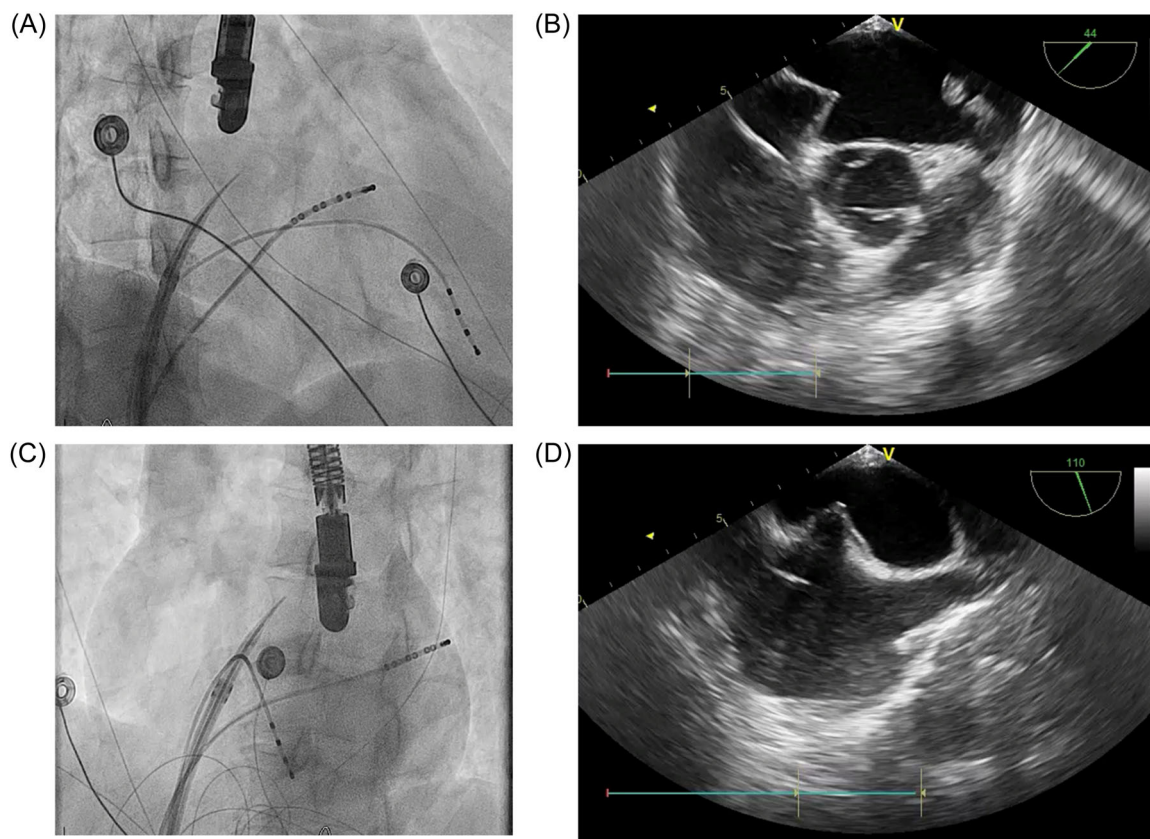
Positioning of the sheath with transseptal needle. (A) Antero-posterior adjustment, fluoroscopy, RAO 30°. (B) Antero-posterior adjustment, TEE short axis. (C) Supero-inferior adjustment, fluoroscopy, LAO 40°. (D) Supero-inferior adjustment, TEE bicaval view. LAO, left anterior oblique; RAO, right anterior oblique; TEE, transesophageal echocardiography.
